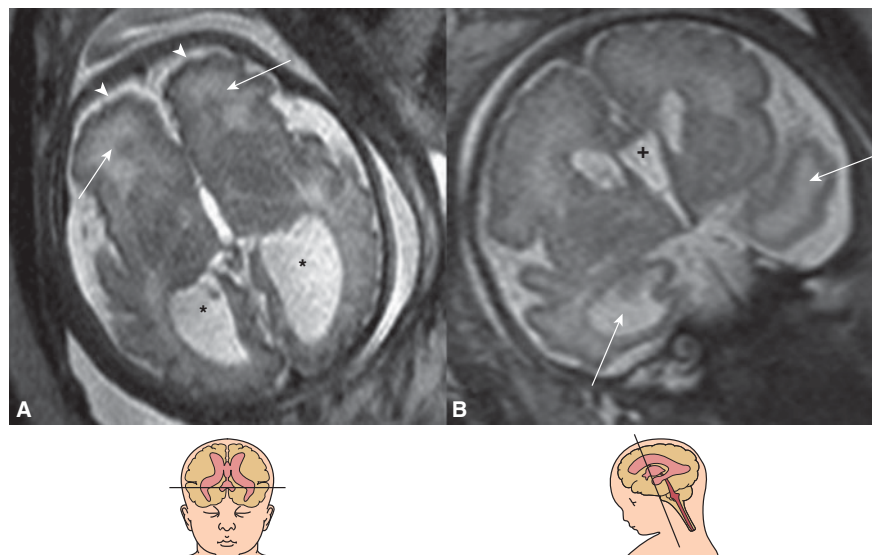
Zellweger syndrome. Brain MRI T2-weighted images in fetus at 35 weeks' gestation. Axial (A) and coronal (B) sections show bilateral frontal polymicrogyria (arrowheads) and abnormally high signal intensity of the frontal and temporoparietal white matter (arrows) consistent with abnormal white matter maturation. Note the presence of asymmetric ventriculomegaly (*) and a large cavum septi pellucidi (+). (Courtesy of Dr. Gregor Kasparian and Daniela Prayer, Vienna, Austria.)
